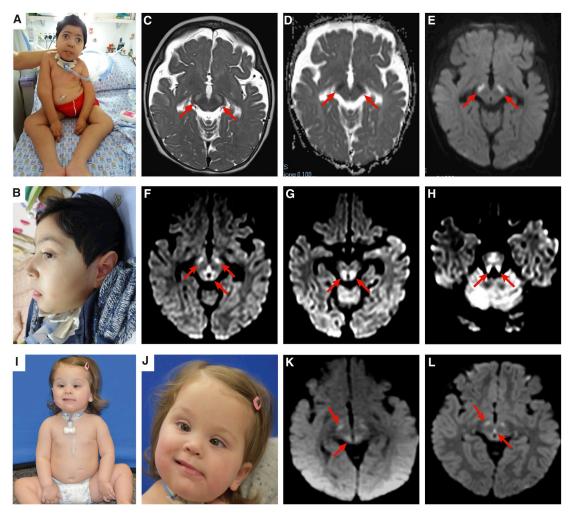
Clinical and MRI Features of the Subjects Heterozygous for the *De Novo CLCN6* c.1658A>G Missense Change (A and B) Clinical features of subject 1, showing mild dysmorphic features, severe generalized hypotonia, blindness, and tracheostomy to treat respiratory insufficiency.
